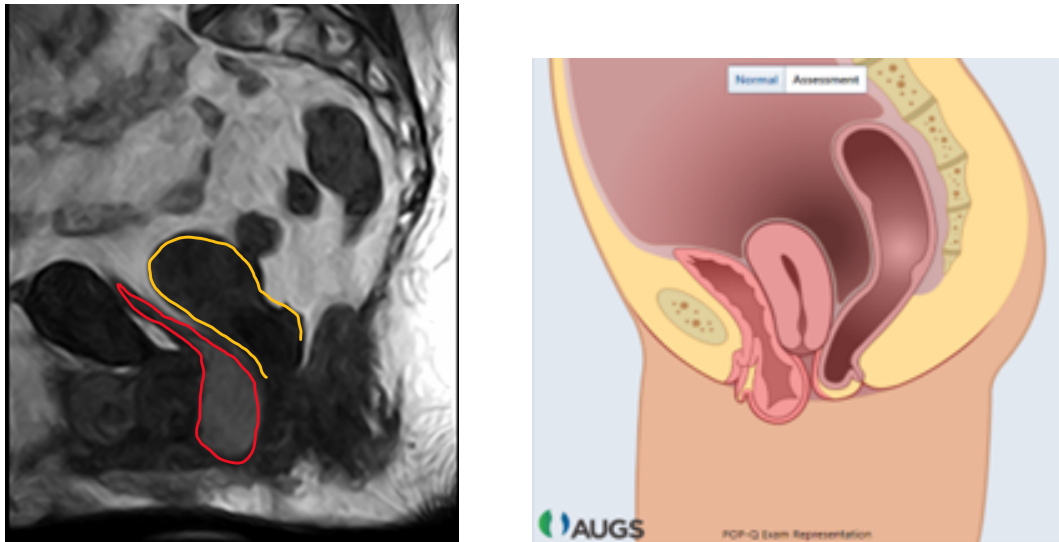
Comparison of MRI to AUGS tool with little to no difference. An example of the MRI scan, with the red outlined bladder and yellow outlined uterus, compared to the AUGS tool with the POP-Q measurements of this patient. The size and location of the bladder show “no” difference with regards to the volume of the bladder below the os pubis. The location of the uterus shows “no” difference.
